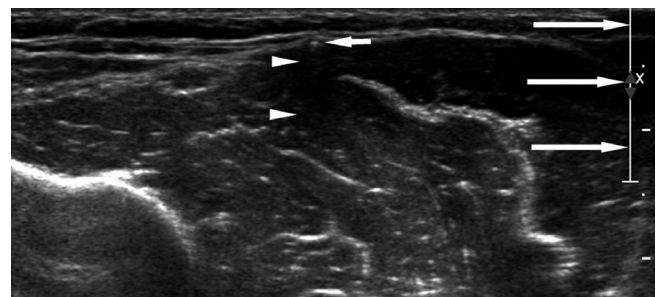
Transverse ultrasonography image of Implanon device in conventional mode obtained from 32-year-old female patient. Echogenic spot (short arrow) indicates Implanon rod. Note unexpectedly ambiguous posterior acoustic shadowing (PAS) (arrowheads) cast posterior to Implanon. Linear bar seen on right side of image (long arrows) corresponds to width of focus depth, indicating that this image was obtained using wide focal zone.
